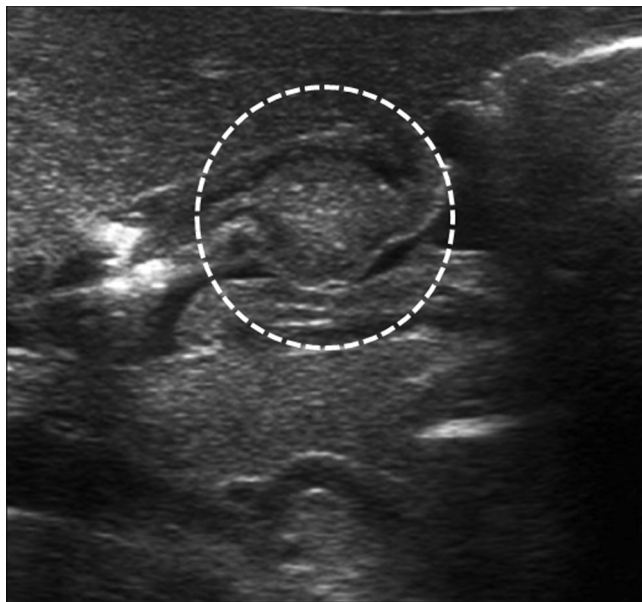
Abdominal ultrasonography at the age of 7 days revealed submucosal mass at the anterior wall of prepyloric antrum (dotted circle).
